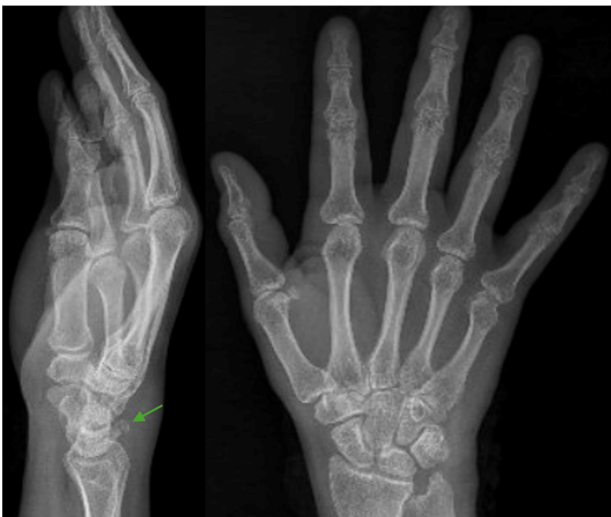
Lateral wrist radiograph showing a non-displaced dorsal cortical fracture of the triquetrum in a 48-year-old female patient. A white arrow indicates the fracture line (“pooping duck” sign).
